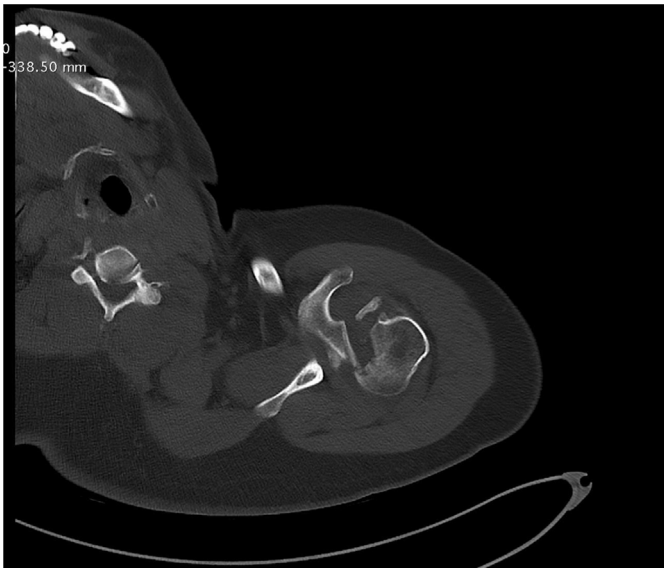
Axial computed tomography of the left shoulder demonstrating the impacted fracture of the humeral head with posterior subluxation.
